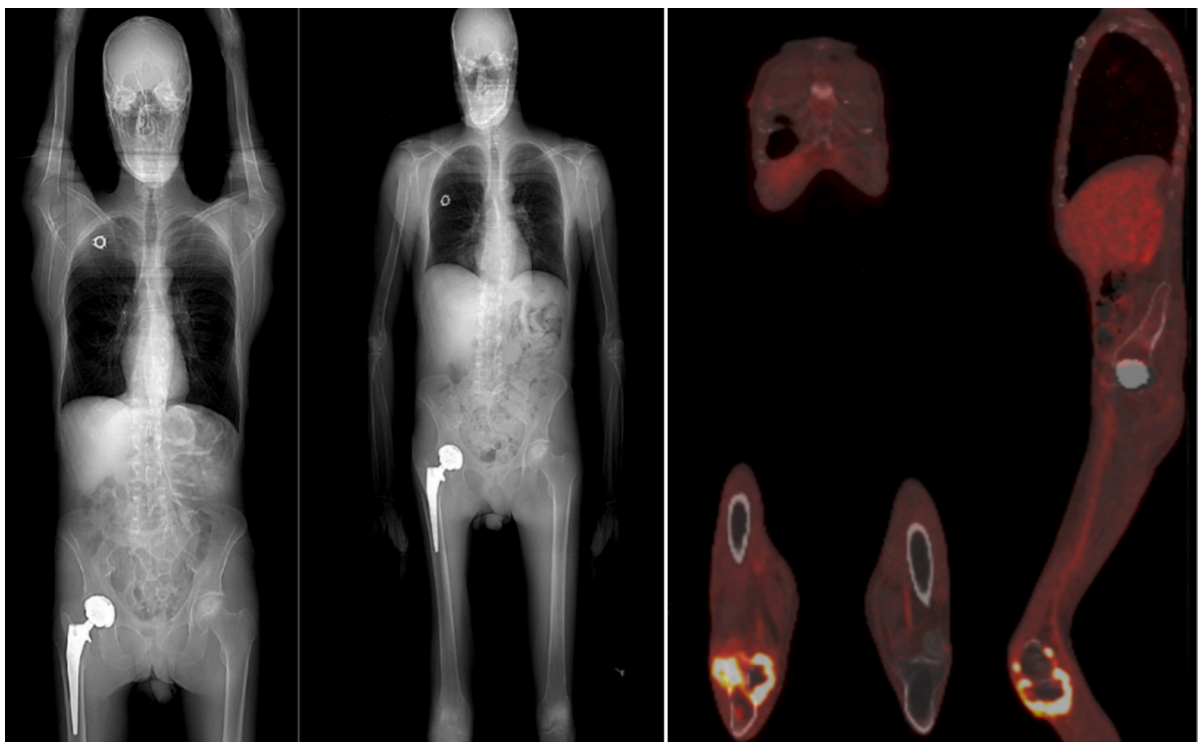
(a) recommended FDG-PET scout: extends from the base of the skull to the upper third of the thigh. (b) extended FDG-PET scout after discussion with the nuclear radiologist to extend beyond the popliteal fossae. (c): extended FDG-PET: showing an intensely hypermetabolic range of the right tibial plateau (SUV max 18.19 with central hyperuptake).
